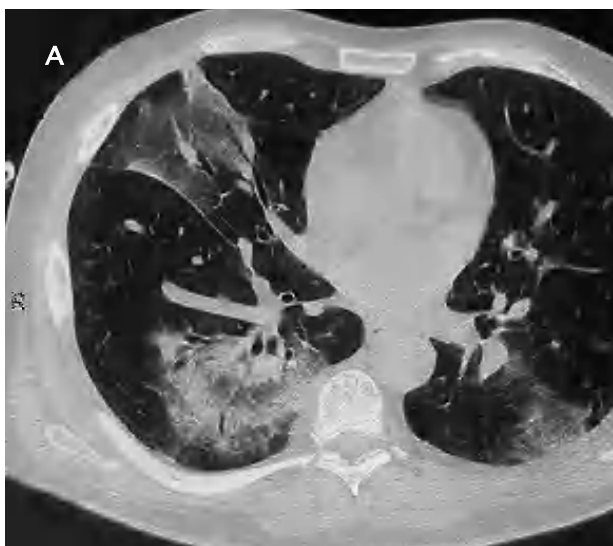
High-resolution computed tomography of the point of entrance of the pulmonary veins (A): ground glass opacity with dilated bronchioles in the middle lobe and peribronchovascular pseudonodular consolidation with the halo sign in the lower right lobe. Axial scan of 1mm collimation at the level of the basal pyramids (B): pseudonodular parenchymal consolidation with reversed halo sign in the left lower lobe and to a lesser extent in the right lower lobe.
